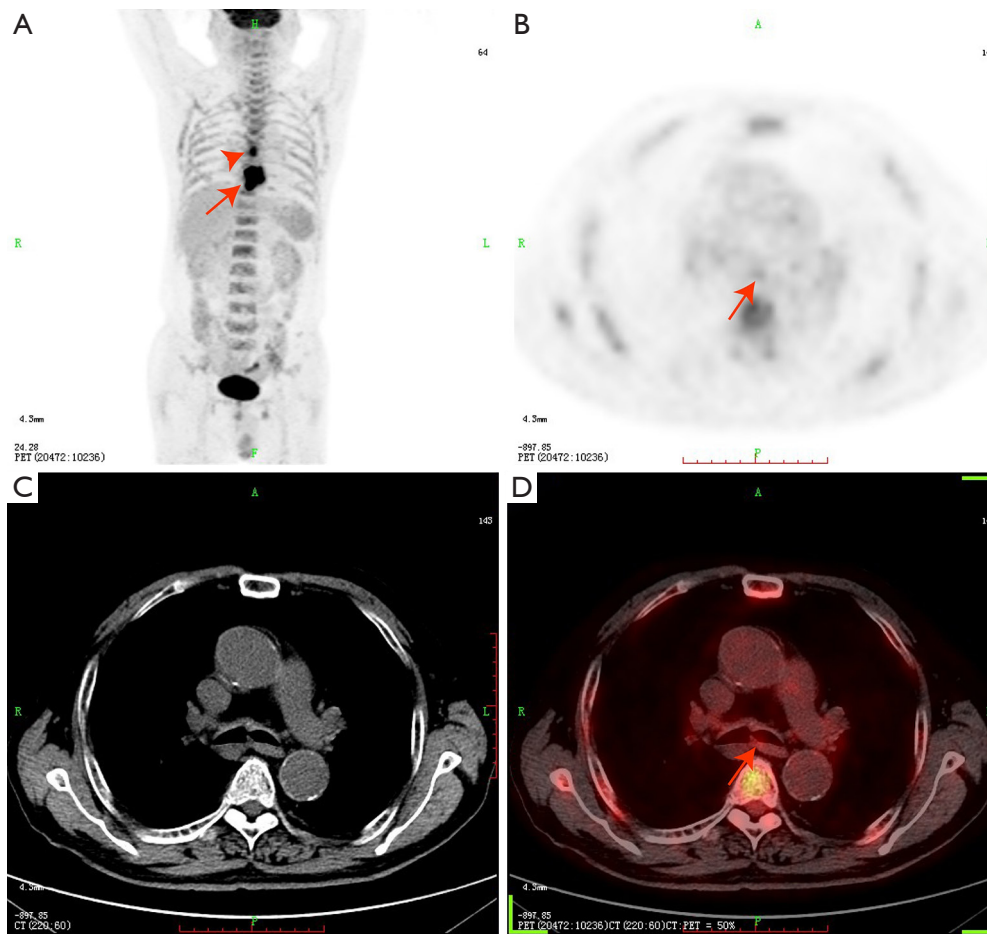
A primary lesion of the left main bronchus, a secondary lesion of the esophagus and a metastatic lymph node in the mediastinum. (A) The metastatic lymph node in the mediastinum and esophageal lesion are displayed in the maximum intensity projection image (red arrowhead and arrow). (B) PET image displayed the primary lesion (red arrow) at the beginning of the left bronchus. (C) No positive findings were found on axial CT. (D) PET/CT image demonstrated the primary lesion (red arrow) at the beginning of the left bronchus increased ^{18}F -FDG uptake. PET, positron emission tomography; CT, computed tomography; ^{18}F -FDG; ^{18}F -fluorodeoxyglucose.
